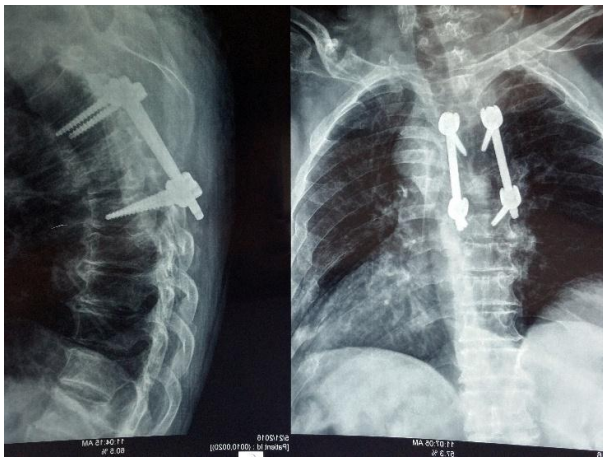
Plain X-ray anteroposterior and lateral views after surgical decompression and fixation
